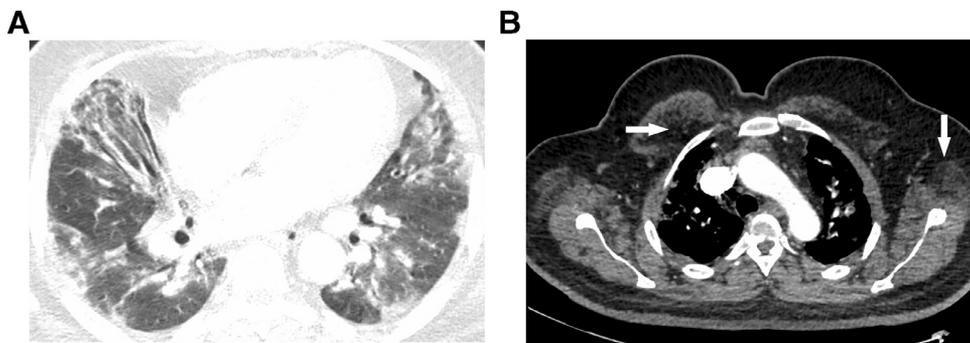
A 49-year-old female with polymyositis presenting with shortness of breath. (A) Contrast-enhanced chest CT (lung window settings) shows peripheral and peribronchovascular consolidation and ground-glass opacity consistent with organizing pneumonia. (B) Soft tissue windows settings shows striking atrophy of several chest wall muscles (*arrows*).
